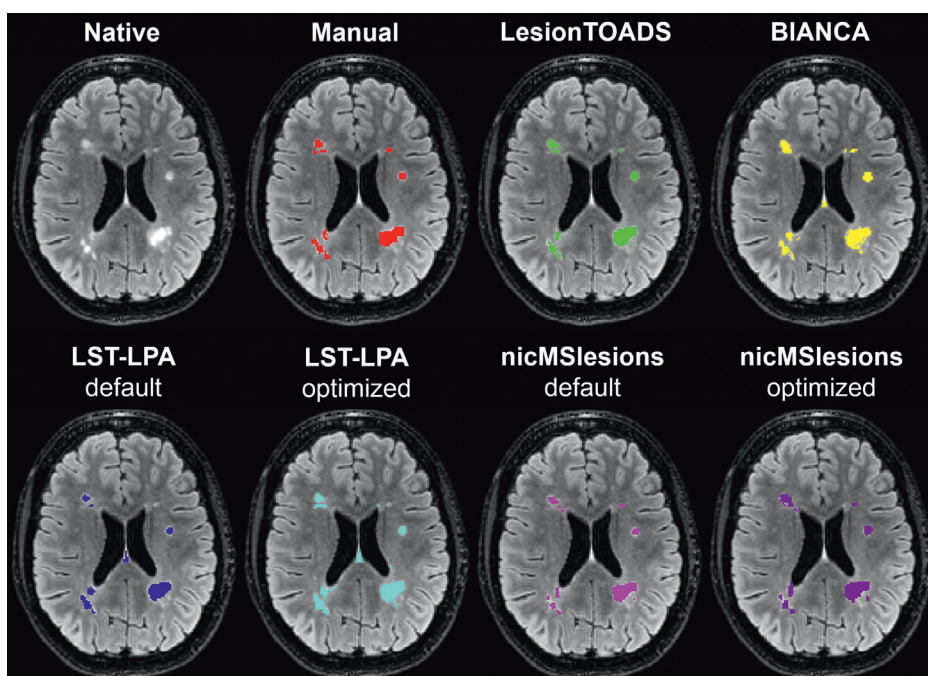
Example lesion segmentation shown for the different lesion segmentation methods on the original 3D FLAIR image of a 36 year old female with RRMS: manual (red); LesionTOADS (green), BIANCA (yellow), LST-LPA default (blue), LST-LPA adjusted-threshold (turquoise), nicMSlesions default (pink), and nicMSlesions optimized (purple).
